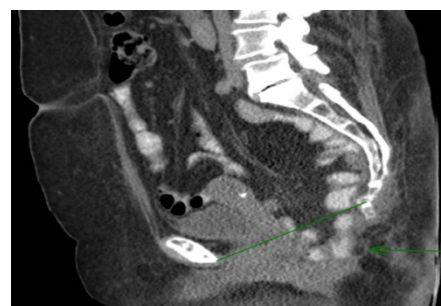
Sagittal computed tomography of the abdomen demonstrating a perineal hernia.
